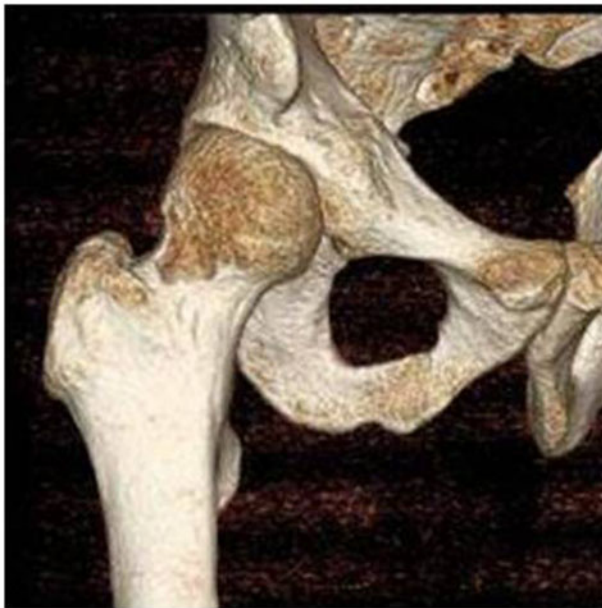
The 3D CT view of femur head-neck area after arthroscopic surgery.
